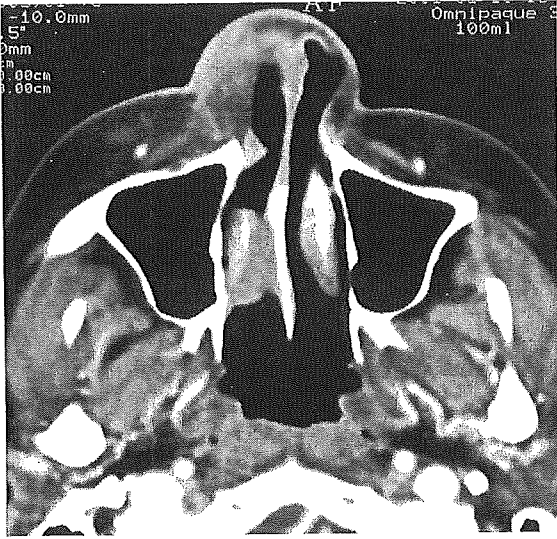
Computed tomography taken before treatment of Case 1. The tumor can be detected in the patient's nasal cavities.
